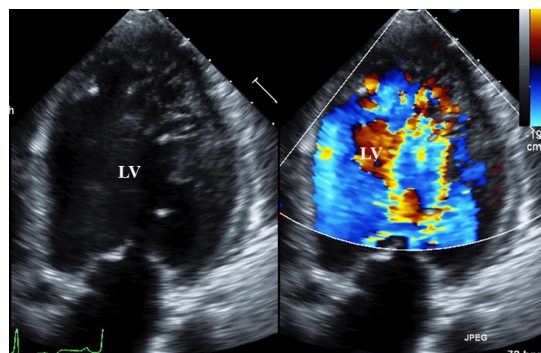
2D echocardiogram of the left ventricle in the apical two chamber view with and without color flow Doppler. This view demonstrates the flow of blood between the trabeculae. [LV-left ventricle]
